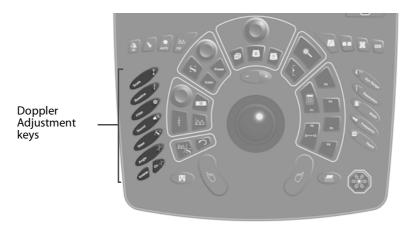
The Doppler Adjustment keys on the control panel.
